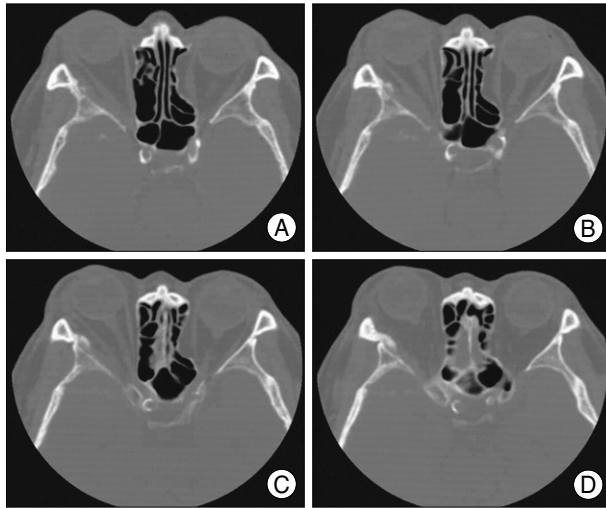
Axial computed tomography scans show irregular bony destruction with sclerotic change of the right sphenoid wing.
